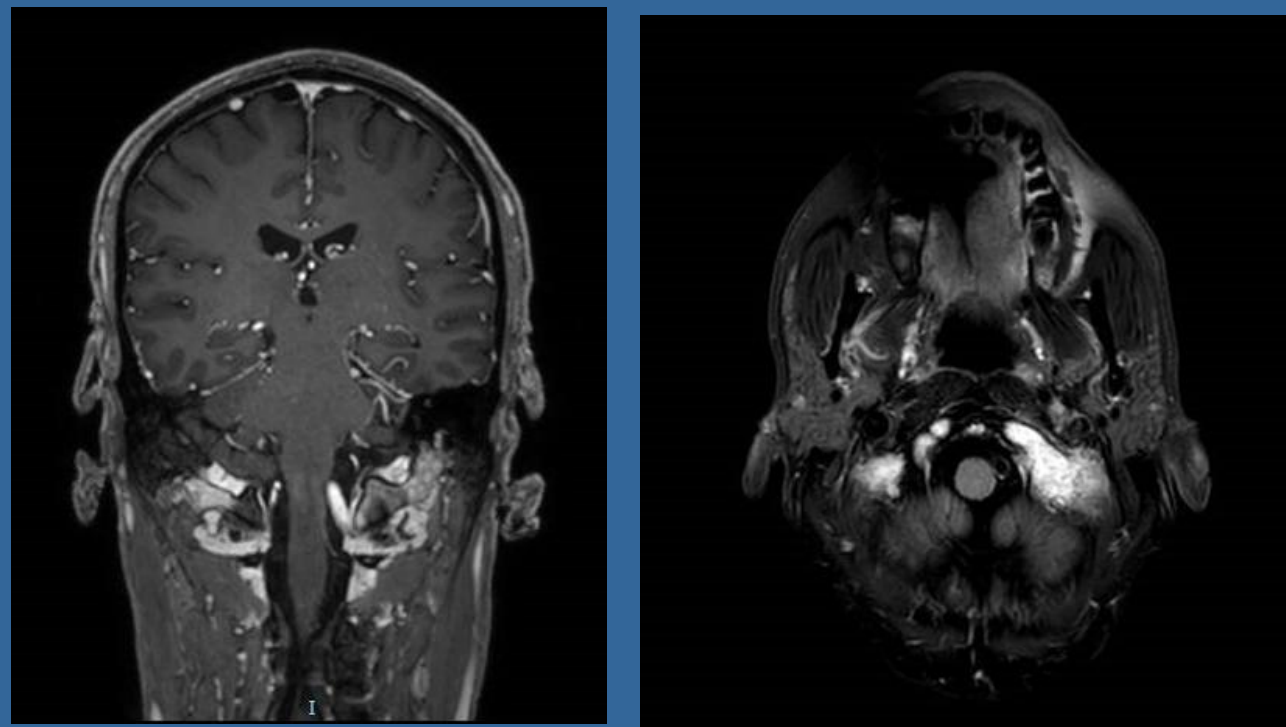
MRI imaging demonstrating skull base metastases
